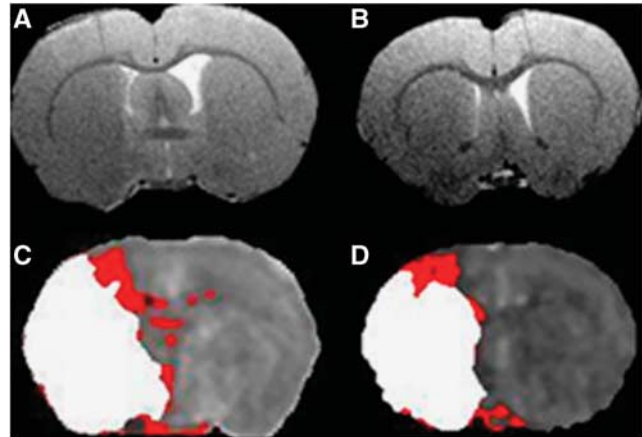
RARE T₂ neuroanatomical templates for caudal (A) and rostral (B) middle cerebral artery territory slices of interest. Corresponding coregistered perfusion-weighted imaging (PWI) and diffusion-weighted imaging (DWI) threshold images displaying DWI lesion (white) superimposed on perfusion deficit (red), revealing DWI/PWI mismatch areas for caudal (C) and rostral (D) slices.
